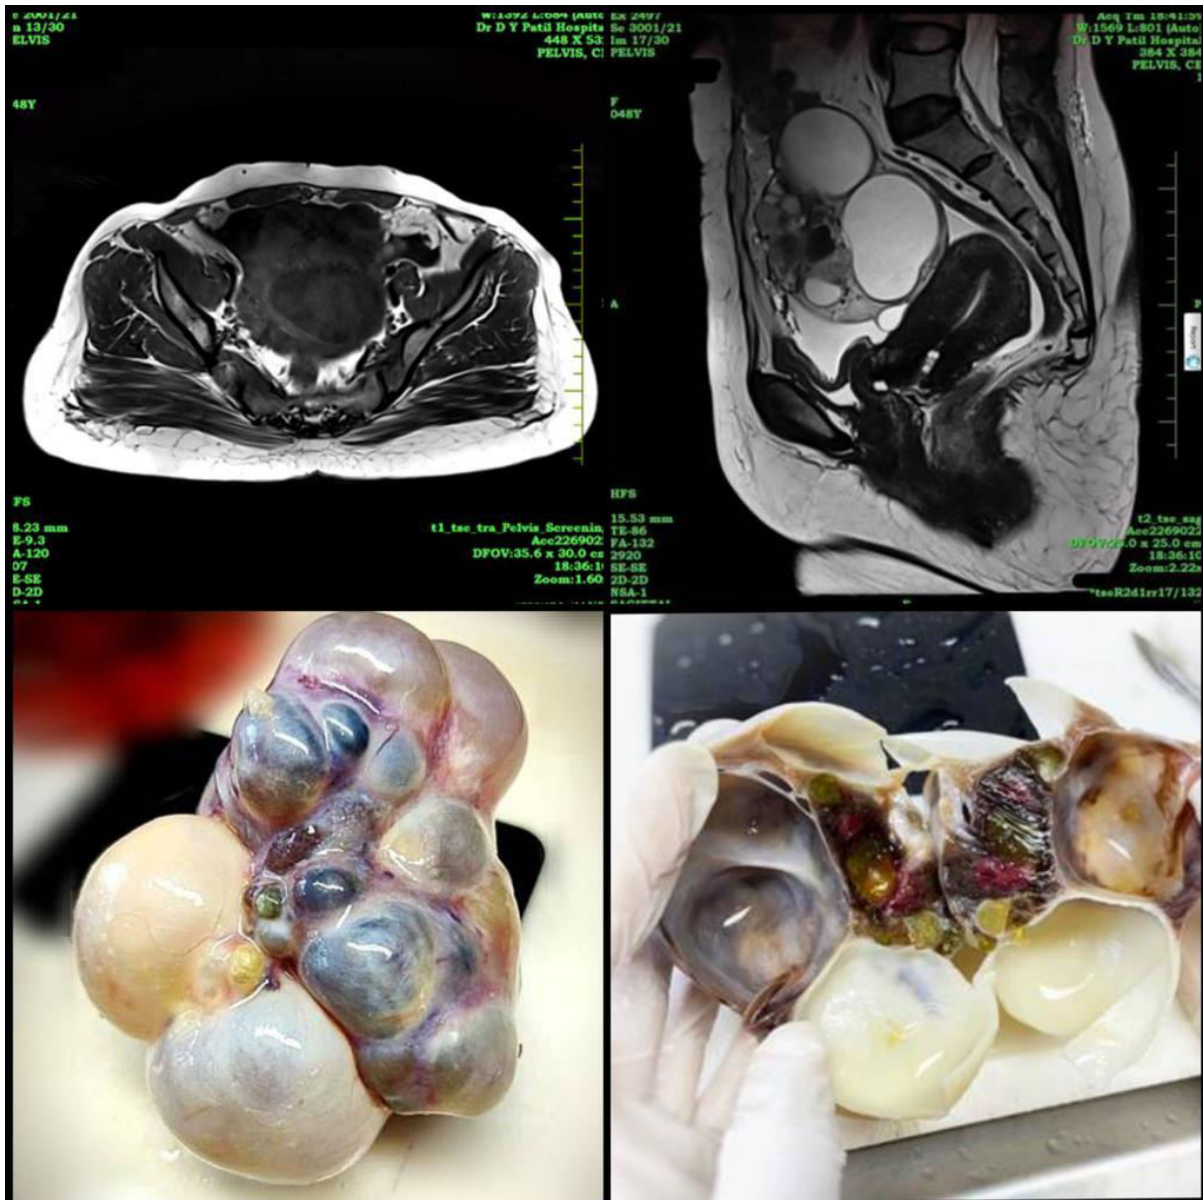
(A-D): MRI image showing large, heterogenous multicystic lesion in pelvis. (A,B) Gross images show a bosselated external surface with areas of congestion. (C) Cut surface shows multiple locules of the cystic lesion. (D)
